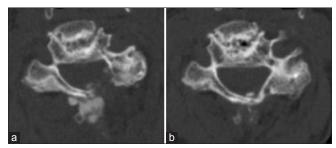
Postoperative CT scans at the C3/4 level. (a) Three days after the operation, residual calcified masses were observed posterior to the lamina of C4. (b) Seven months after the operation, new bone had formed in the involved lamina and facet of C4
